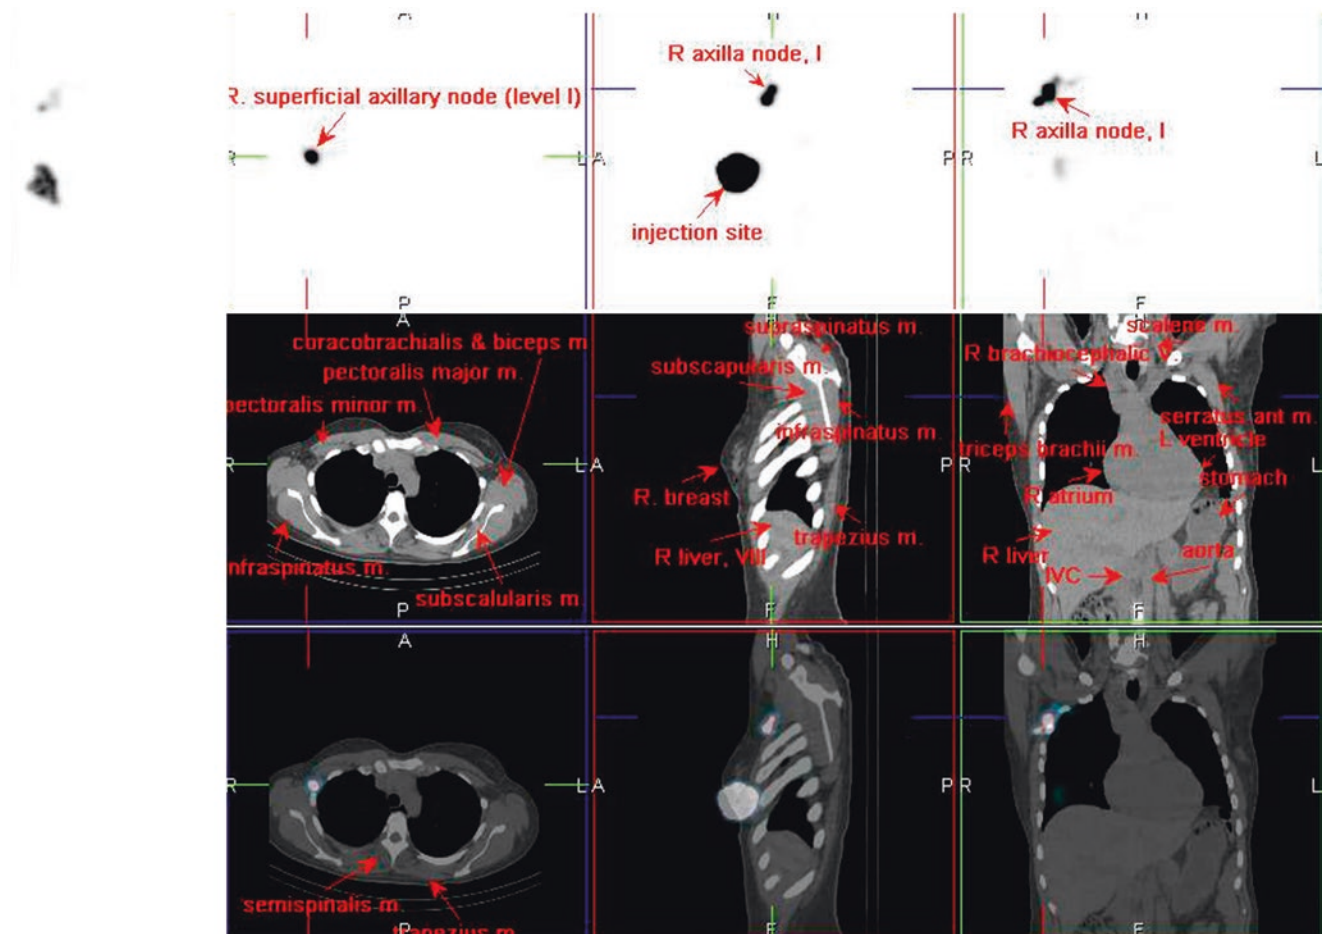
^{99m}Tc -filtered sulfur colloid SPECT/CT
